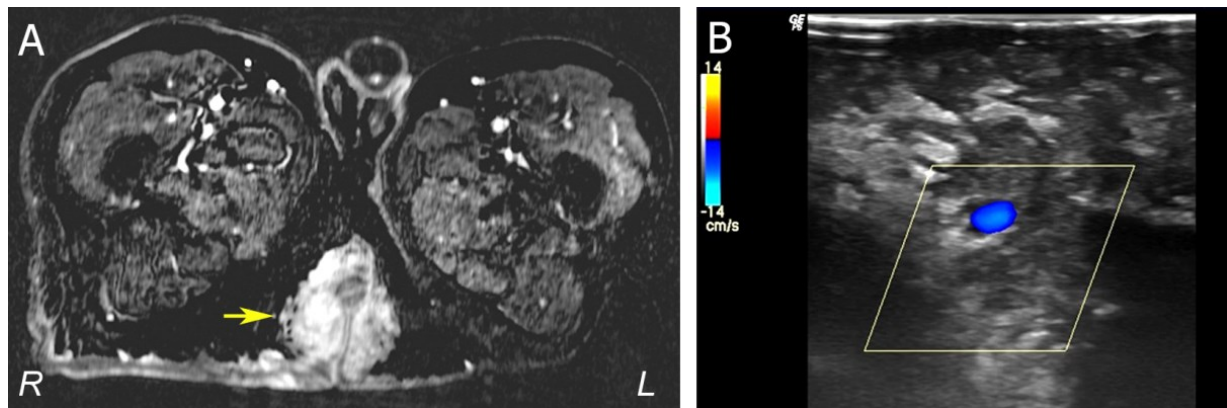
A. T1-weighted MRI cross-section through lower pelvis showing vascular spaces penetrating the hyperintense nevus tissue (yellow arrow; R, right; L, left). B. Duplex sonography showing spongiotic vascular malformation (darker areas) infiltrating the nevus tissue (lighter areas). An exemplary vein is shown in blue, measuring 0.36 cm in diameter at a depth of 5.5 cm.
